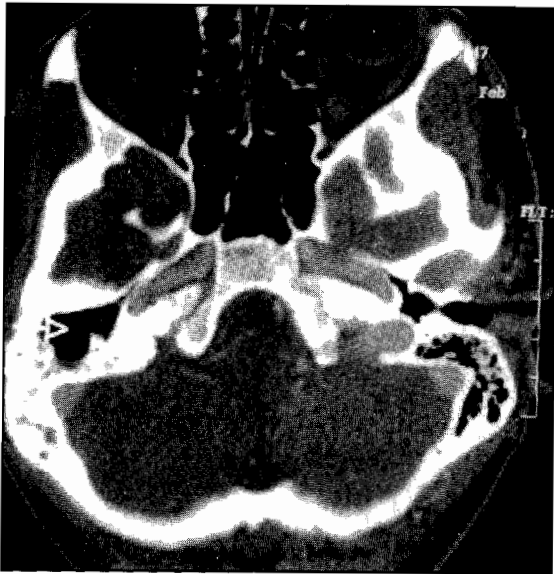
CT scan of right mastoid bone with the arrow showing the right mastoid cavity with the air cells destroyed by the disease process.
